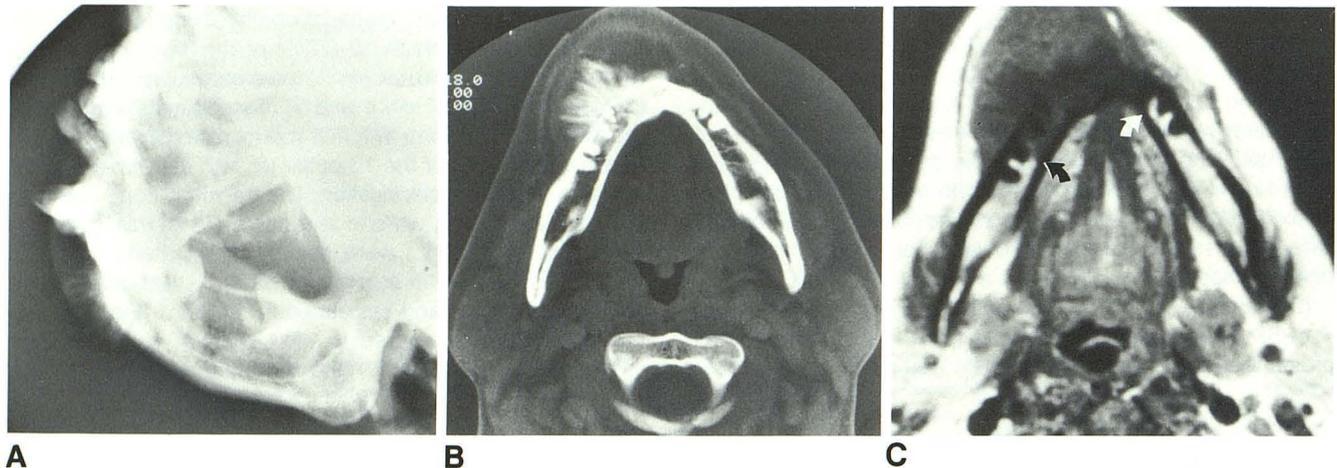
Right mandibular chondroblastic osteosarcoma in 40-year-old woman. A–C, Plain film (A), CT (B), MR (C) of extensive spiculate pattern of parosteal reaction, best demonstrated on CT. However, MR, in T1-weighted pulse sequence, shows to best advantage the extent of medullary involvement (arrows in C).
